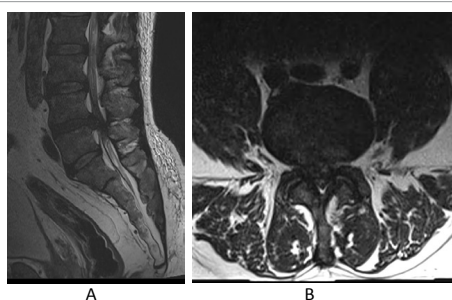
Pre op sagittal and axial MRI images showing a large central L4-L5 disc with severe cauda equina compression.
